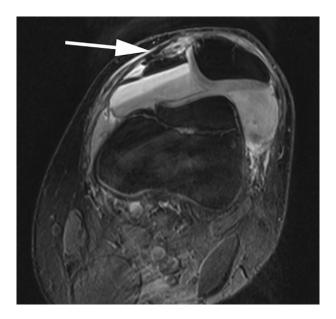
MRI showing axial view of the patella. Massive hemarthrosis and lateralization of the patella are visible with disruption of the MPFL (arrow) and a dislocated osteochondral flake. The ACL was intact besides a partially avulsion at the bony insertion at the femoral fracture site.
